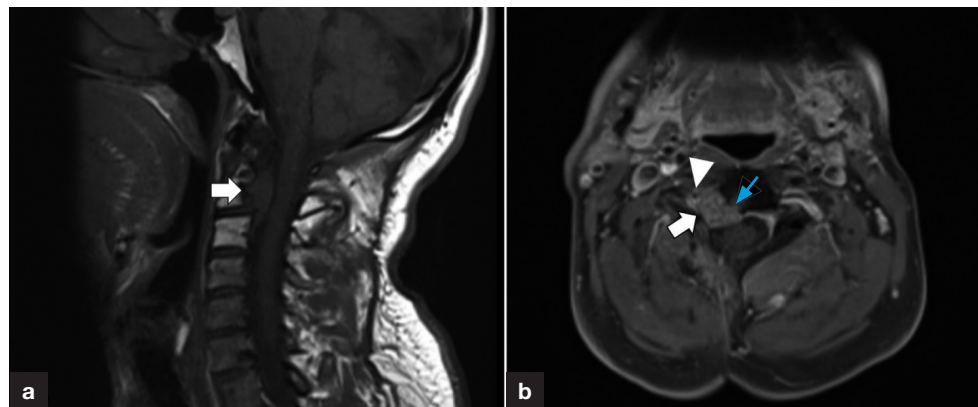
a. Sagittal T1-weighted magnetic resonance scan showed a lobulated epidural mass occupying the right side of the spinal canal at C1–3 level in the midline (arrow). b. Axial contrast fat-suppressed T1-weighted magnetic resonance scan showed that the lesion had destroyed the C1 vertebral corpus (blue arrow), extended into the right neural foramen and surrounded the right vertebral artery (white arrowhead).
